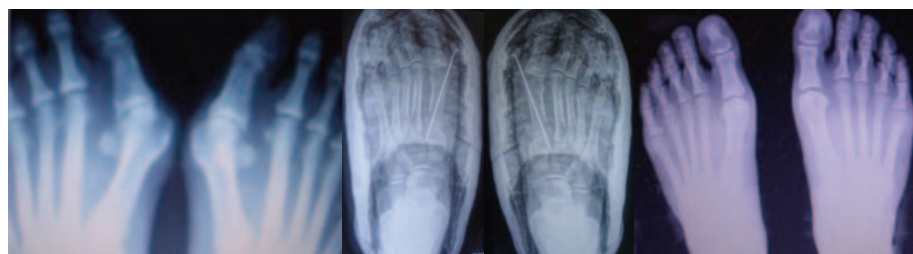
X-ray scan of a 49-year-old patient: left – hallux valgus before surgery; center – postoperative scan of Golden osteotomy; right – two years after surgery scan.
